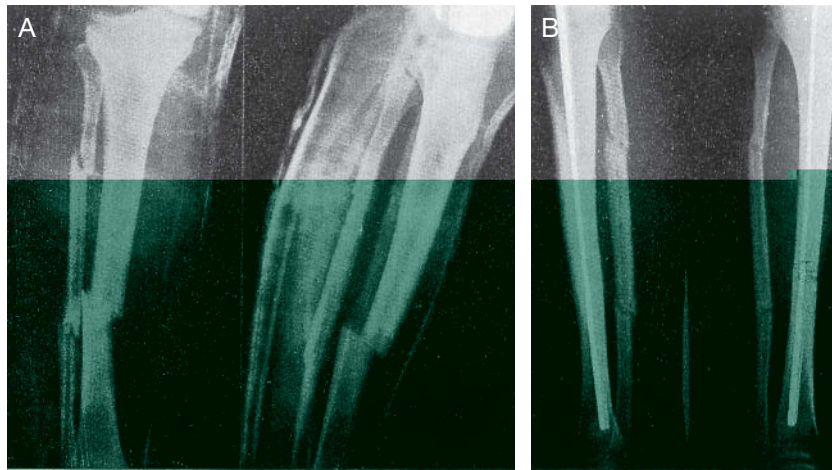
F.M.M. Open transverse tibial and talar fracture. A: Preoperative x-rays. B: X-ray view showing complete bone healing at 1 month. This patient was allowed to return to his occupational activities one and a half months after surgery.
